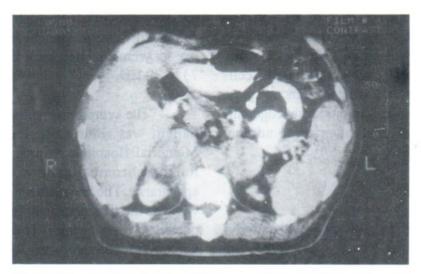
Constrast-enhanced CT scan shows inhomogeneous enhancement of bilateral adrenal masses.
